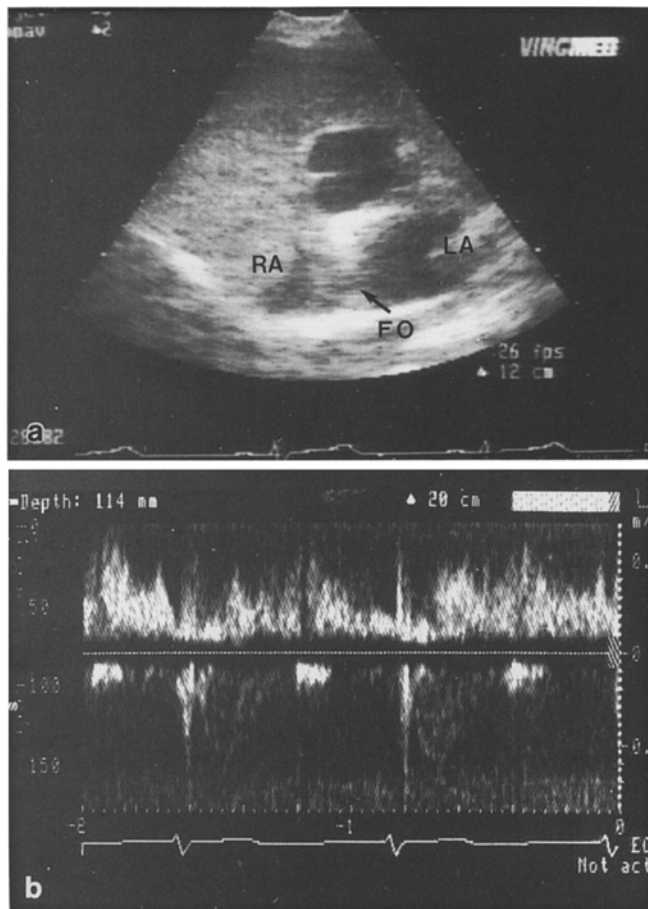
a Contrast echography showing microbubbles and filling defect inside the right atrium close to the foramen ovale (FO). RA, right atrium; LA, left atrium. b Doppler showing high-frequency flux through the inter-atrial septum
